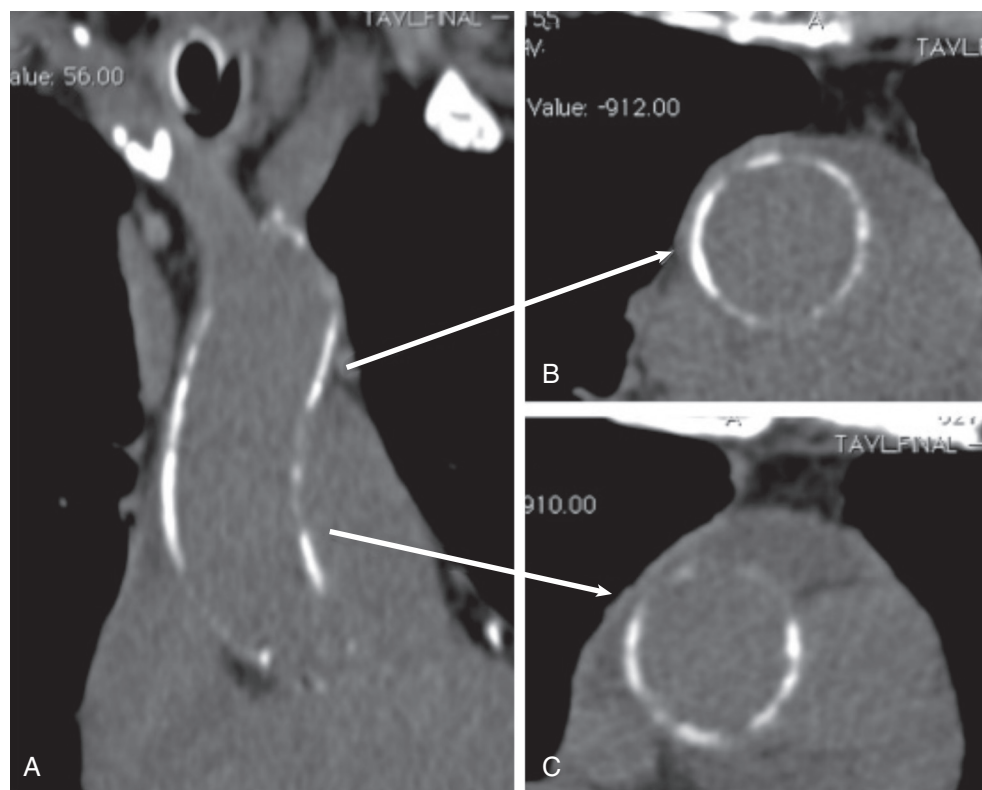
Noncontrast CT showing extensive aortic calcification (“porcelain aorta”). A, In the coronal plane, calcification extends from the aortic sinotubular junction to the aortic arch. B, C, Cross-sectional images (at levels indicated by arrows extending from A) from the upper (B) and lower (C) ascending aorta show the circumferential nature of the calcification.
